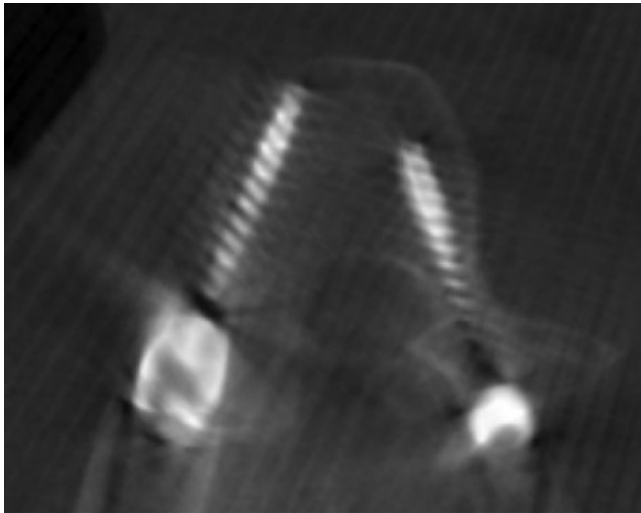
Postoperative CT scanner showing extrapedicular 'safe' trajectory of the right pedicle screw.
